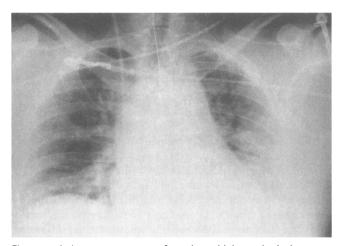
A chest roentgenogram of a patient with leptospirosis shows cardiomegaly and diffuse bilateral infiltrates.
